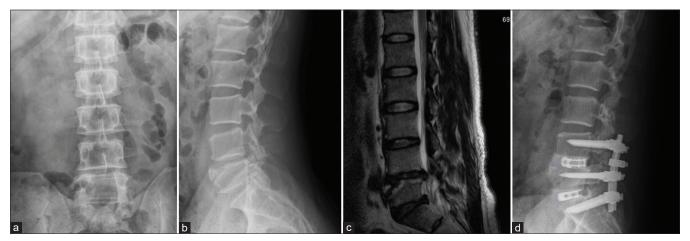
(a and b) Preoperative radiographs of a 34-year-old male with painful disc showing disc space narrowing of L4/5. (c) A preoperative magnetic resonance image showing a dark disc with herniation of L4/5 and L5/S1. (d) A lateral postoperative radiograph at final follow-up showing solid fusion after 2-level PLIF
